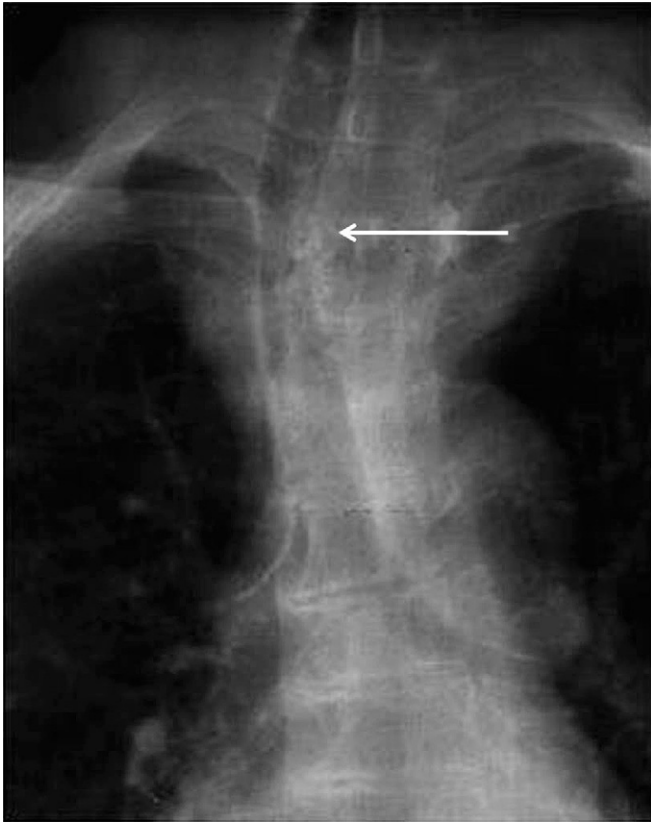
Chest radiography. There is lateral deviation of the trachea (arrow).
